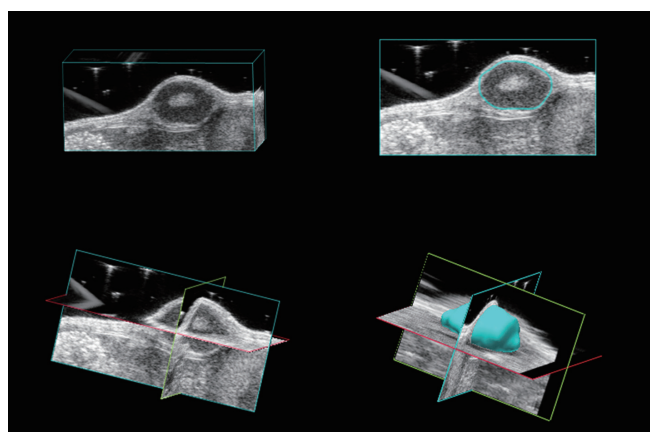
Tumor volume measurement using high-resolution three-dimensional (3D) ultrasound. Tumors were scanned using 3D mode under respiratory gating. Tumors in captured 3D images were manually contoured along tumor margin. Then, tumor volume was automatically calculated using parallel segmentation in Vevo2100 software.
